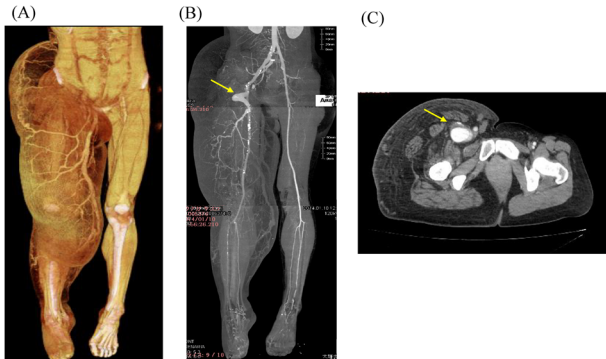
(A) Plane CT shows abnormal dilated superficial veins and giant extremity with lymphedema. (B) Contrast CT angiography shows dilated and calcified iliofemoral arteries, a deep femoral artery aneurysm in the right groin (arrow), and earlier venous filling in the right lower limb. (C) Axial CT. A deep femoral arterial aneurysm at the right groin (arrows), atrophy of the muscles, and typical findings of lymphedema of the thigh were observed.
